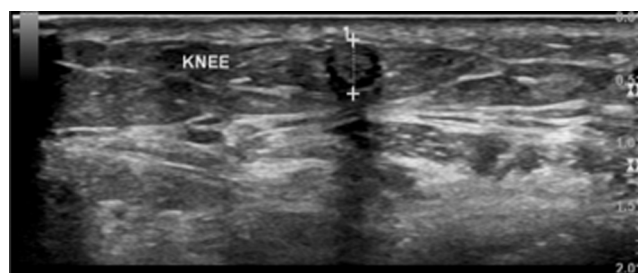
Ultrasound demonstrated echo-dense vessel with no venous flow.
